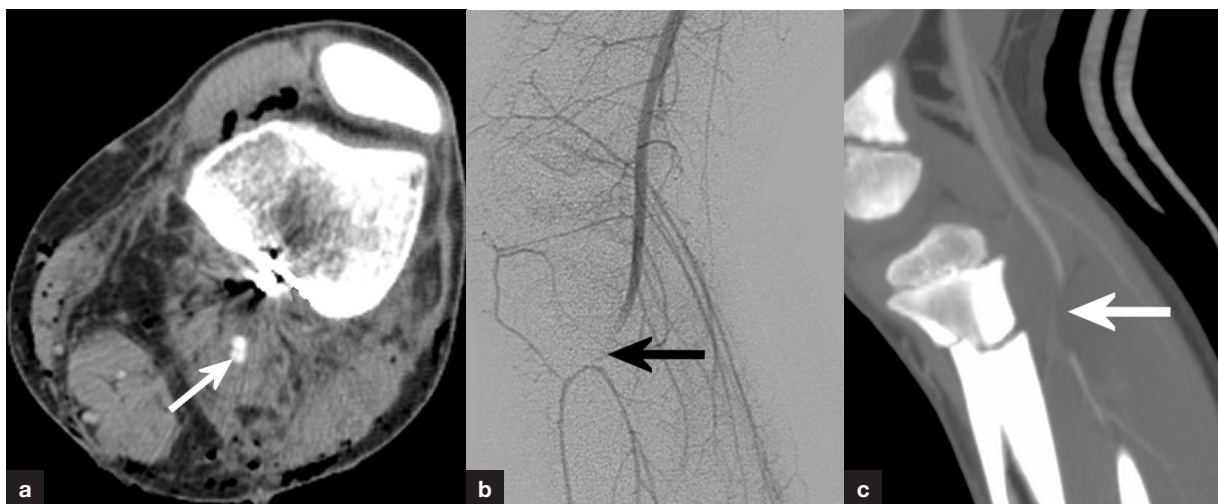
Computed tomography angiogram and conventional arteriogram demonstrating radiological signs of arterial injury. a. Computed tomography angiogram displaying loss of opacification of the popliteal artery in association with proximal tibial fracture. b. Conventional arteriogram of the same limb as Figure 3a demonstrating distal filling defect. c. Computed tomography angiogram showing contrast extravasation from the axillary artery, no bony injury demonstrated here.
